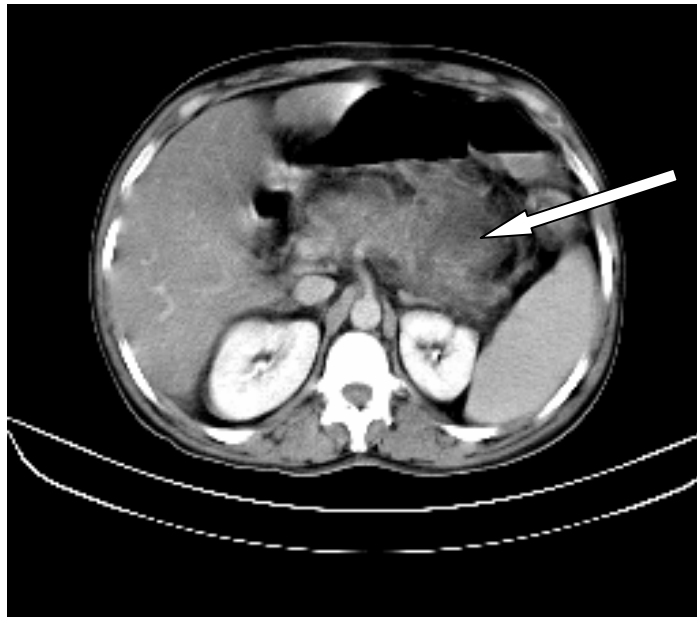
FIGURE # 15 : CONTRAST ENHANCED CT ABDOMEN AXIAL SECTION OF DELAYED PHASE SHOWING A SUBTLE MASS LESION INVOLVING PANCREATIC HEAD(ARROW) WITH PERIPANCREATIC FAT STRANDINGS AND WITH CALCIFICATIONS IN THE TAIL REGION(CURVED ARROW).
